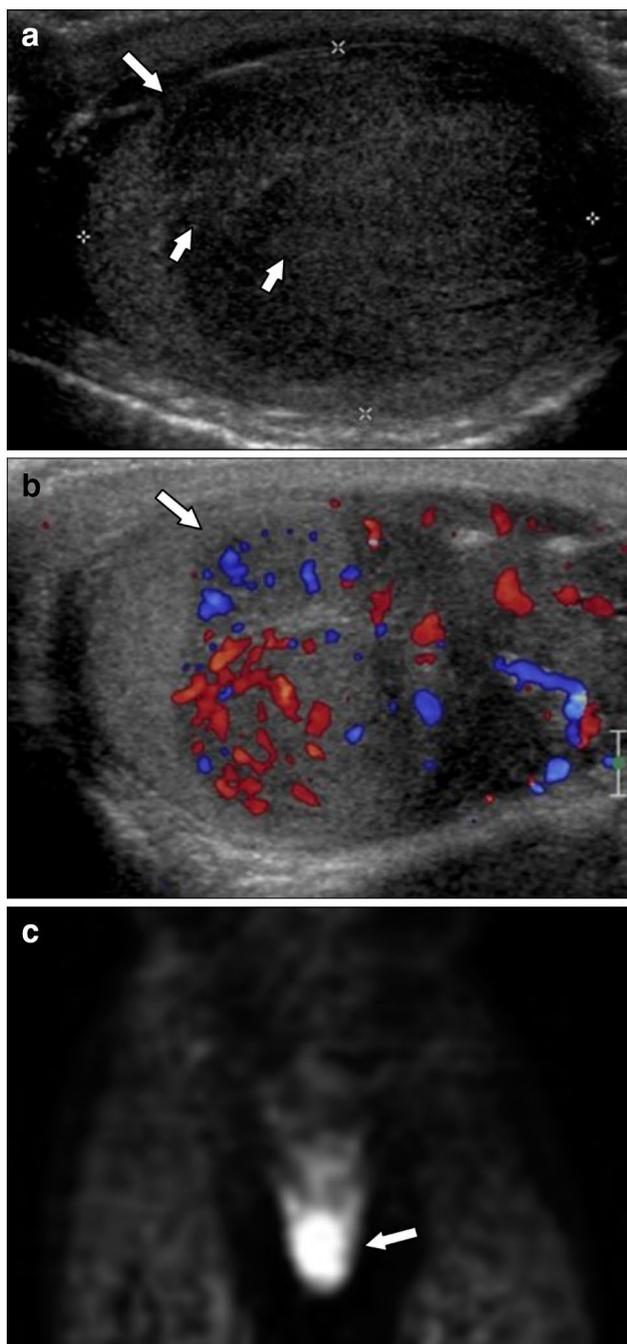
Acute myelogenous leukemia with testicular involvement in a 31-year-old man. Gray scale (a) and color Doppler (b) US images show a hypoechoic, hypervascular mass in the right testis with extra-testicular extension (arrows). Coronal FDG-PET image (c) shows focal hypermetabolic uptake in the testis (arrow). Orchiectomy with subsequent pathology revealed granulocytic sarcoma
